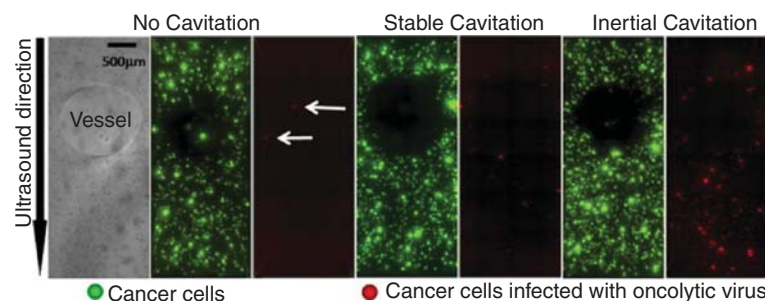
BT-474 cells embedded in tumour-mimicking model containing a vessel; co-administration of SonoVue microbubbles and adenovirus through the flow vessel while 0.5 MHz ultrasound applied at 0 MPa (no cavitation), 360 kPa (stable cavitation), and 1.25 MPa (inertial cavitation). Extravasation of the oncolytic virus is greatly enhanced in the presence of stable and in particular inertial cavitation, with much of the enhancement being observed in the direction of sound propagation.
